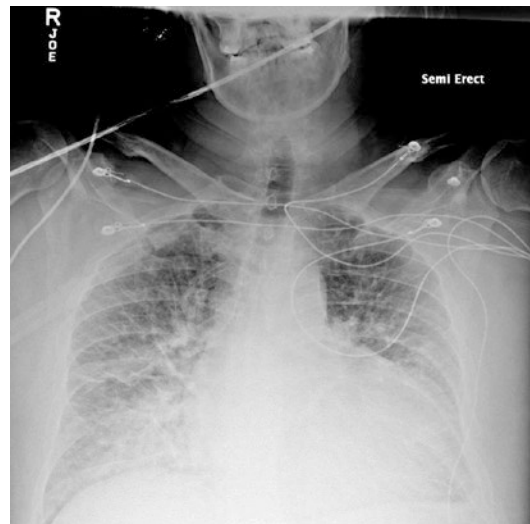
Initial chest x-ray with evidence of pulmonary edema and widened mediastinum
